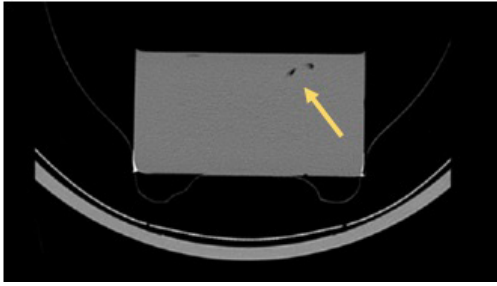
CT of the model. Air.
